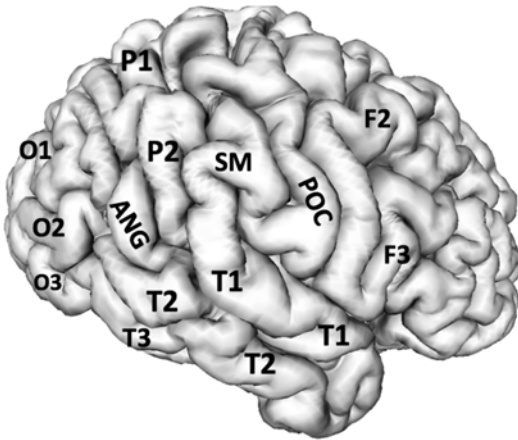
3D MRI reconstruction. F2 and F3 are seen to take root from and are continuous with the precentral gyrus. The postcentral gyrus is continuous superiorly with the superior parietal lobule (P1) and inferiorly with the supramarginal gyrus (P2 or inferior parietal lobule). In this individual, the superior pli of the postcentral gyrus with P1 is more inferiorly located than is typical. P1 becomes O1. T1 can be identified merging with the supramarginal gyrus. T2 contributes both to the angular gyrus and O2. T3 continues posteriorly to become O3. ANG angular gyrus, SM supramarginal gyrus, POC postcentral gyrus
